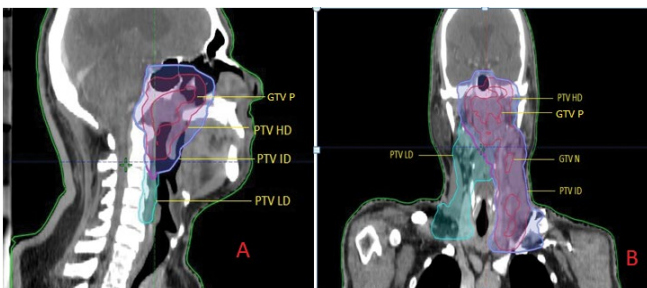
(A) Sagittal section of planning CT scan image showing Planning Target Volumes (PTV). (B) Coronal section of the planning CT scan depicting PTVs. PTV HD- high dose PTV, PTV ID -intermediate dose PTV, PTV LD-low dose PTV, GTV P- gross tumour volume primary, GTV N- gross tumour volume nodes
